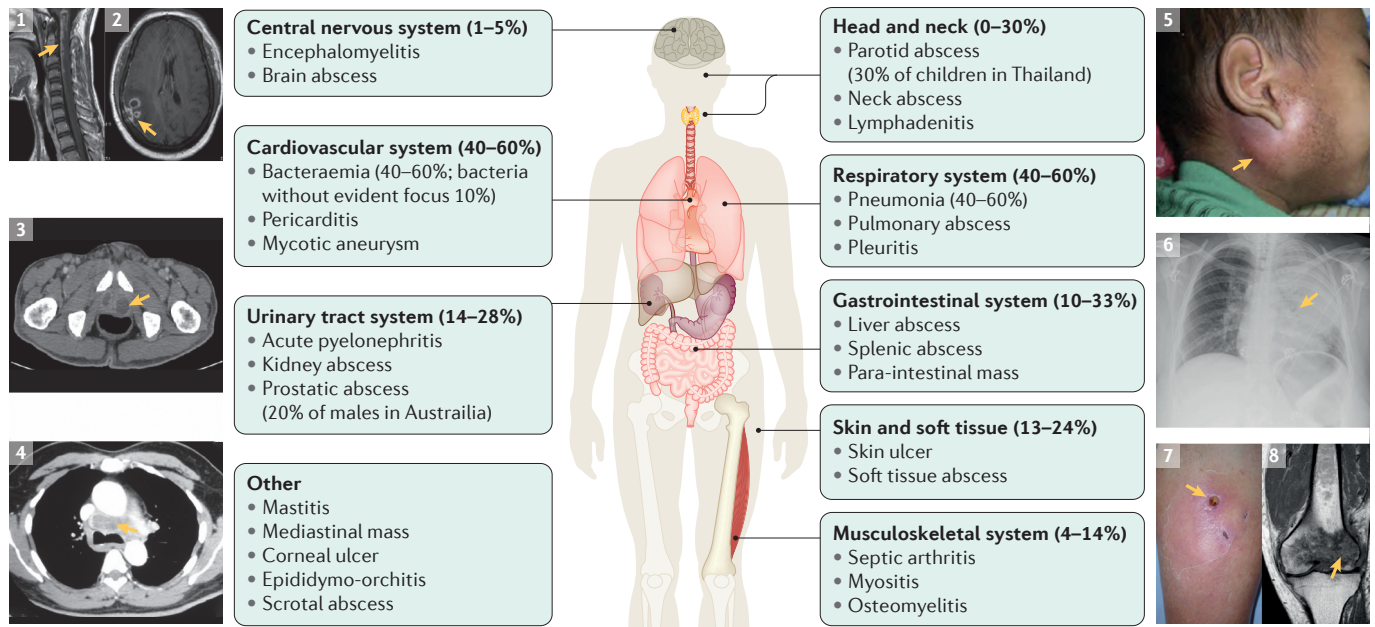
Clinical manifestations of melioidosis. Examples of possible clinical presentations of melioidosis: an MRI of the brainstem and cervical spinal cord with inflammatory changes consistent with encephalomyelitis (arrow, part 1); a ring-enhancing lesion with surrounding oedema in the MRI image indicating cerebral abscesses (arrow, part 2); a CT image of prostatic abscesses (arrow, part 3); a CT image of a mediastinal mass (arrow, part 4); a child with tense parotitis (arrow, part 5); X-ray image of severe pneumonia (arrow, part 6); photo of a subcutaneous abscess (arrow, part 7); and an MRI image of osteomyelitis of the distal femur with surrounding inflammation (arrow, part 8). Clinical images 1–4, 6–8 courtesy of Bart J. Currie, Menzies School of Health, Australia. Clinical image 5 is reproduced with permission from (REF. 249), Elsevier.
